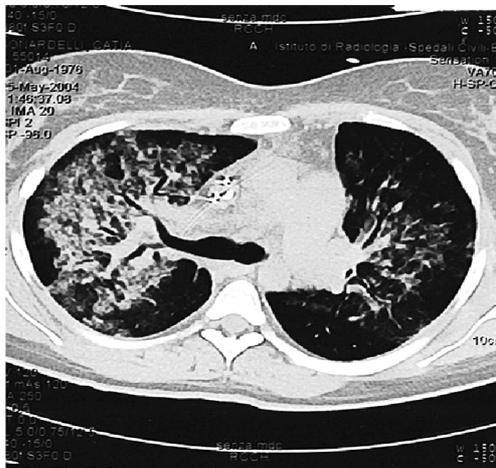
Chest computed tomographic scan confirming the presence of a unilateral interstitial infiltrate.
